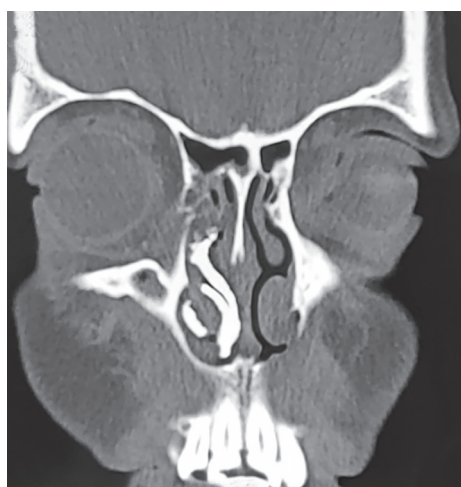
Computed tomography of paranasal sinuses revealed a densely calcified mass seen insinuating the right inferior turbinate and extending laterally to the inferior meatus
